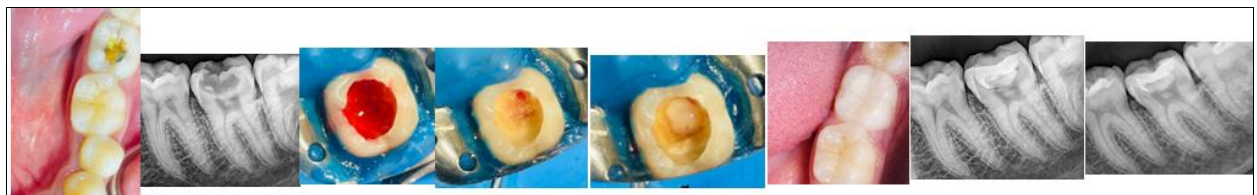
Clinical and radiographic sequence for Case 4: preoperative assessment, caries detection, pinpoint pulp exposure, PRF preparation and placement, immediate postoperative restoration, and 12-month follow-up.
